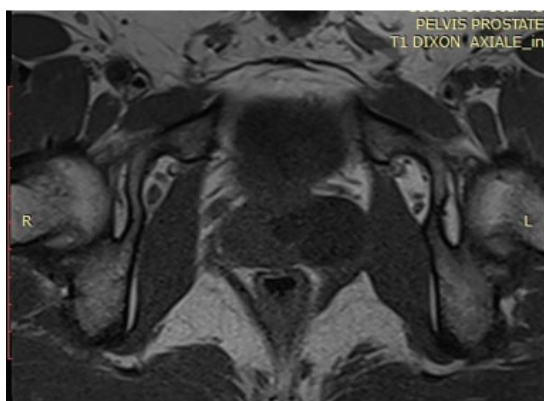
T1 MRI cross-section showing implantation in the prostate.
